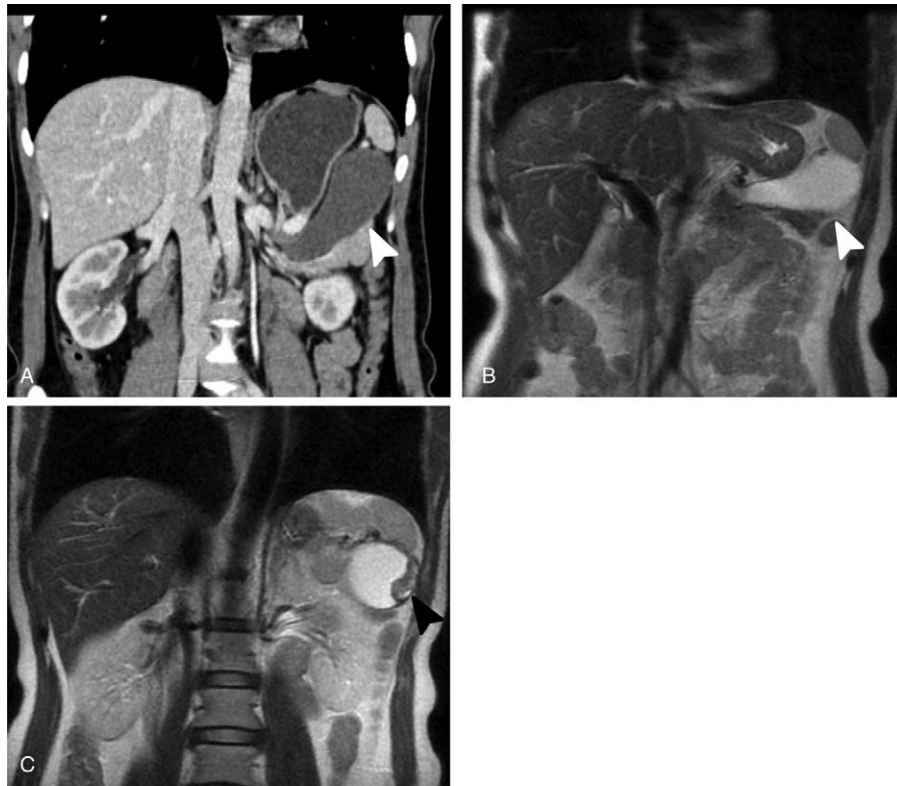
Coronal CT (2017-09-07) and T2WI of MRI (2017-9-18). (A) Coronal CT image showed a well-defined boundary between the ciliated foregut cyst and pancreas. The pancreas was compressed and displaced downward. (B) Just 11 days later, the shape of the cyst was changed, but the volume had no significant change in the imaging. (C) T2WI showed the lesion exhibited homogeneous high-intensity signal with a strip of a low-intensity signal, which may indicate the presence of remote hemorrhage. CT=computed tomography.
